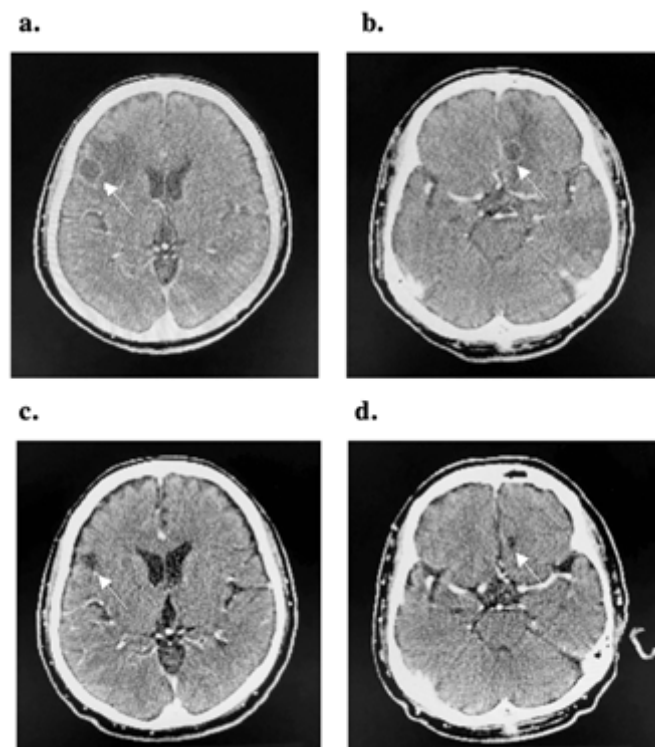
Brain computed tomography image before pembrolizumab treatment showing metastases in the right frontal lobe (a) and left fronto-parietal lobe (b) measuring 1.6 x 1.5 cm and 1.8 x 1.4 cm, respectively, and repeat scan after 7 cycles showing a reduction in the size of the lesion to 1.0 x 0.9 cm (c) and 0.7 x 0.5 cm (d) with no FDG uptake.
